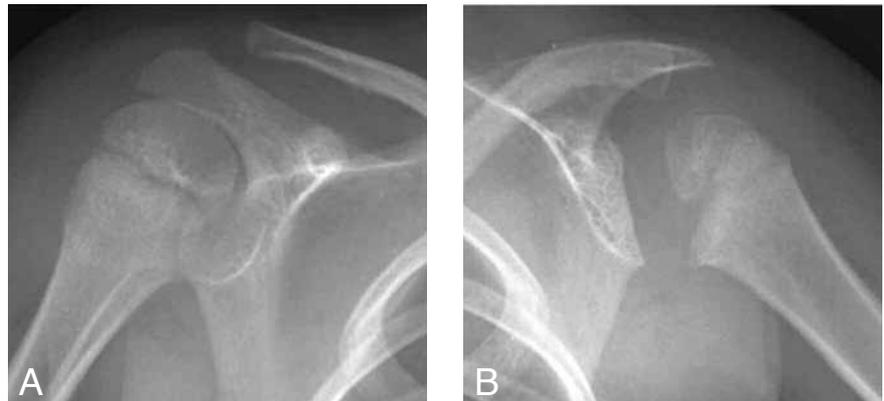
Standard radiograph of the shoulders (A, B) demonstrates an asymmetric, smaller proximal humeral epiphysis on the left side (B) with concomitant glenoid dysplasia.
